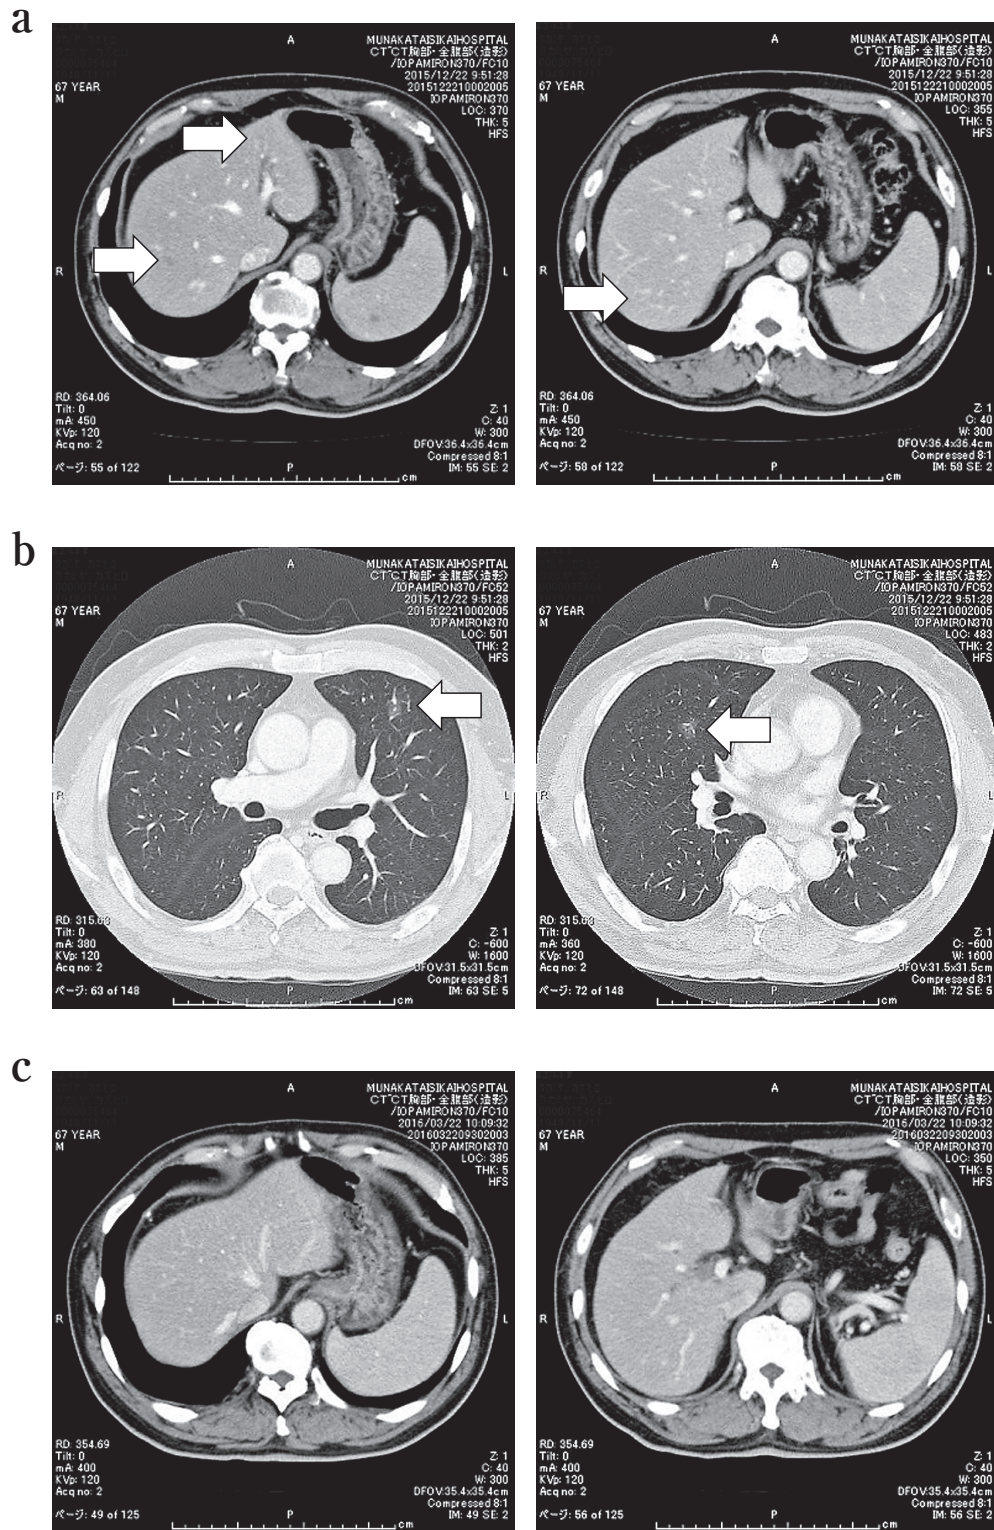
Computed tomography (CT) examination carried out in September 2015. a : Abdominal CT images showing multiple low density areas in the liver, that were diagnosed as multiple metastases (narrow arrows). b : Chest CT images showing multiple ground glass-like shadows in both lungs, that were suspected of being multiple metastases (thick arrows).
